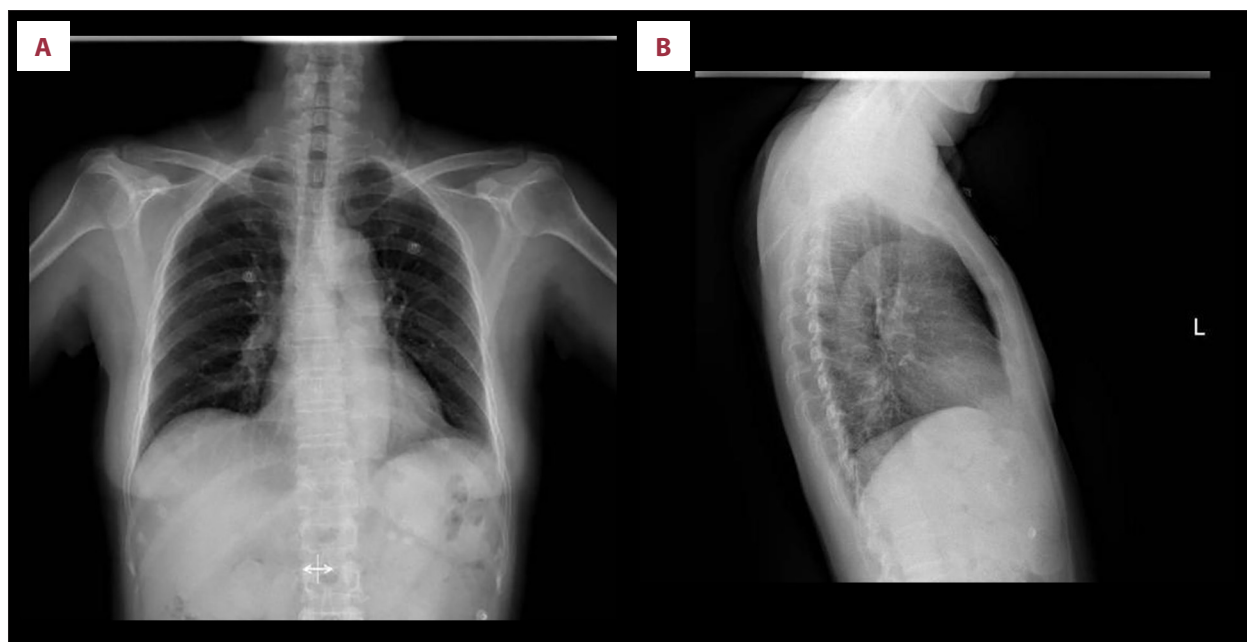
(A, B) Chest radiographs demonstrating no cardiomegaly, normal pulmonary vascular markings, and no acute pulmonary infiltrates.
